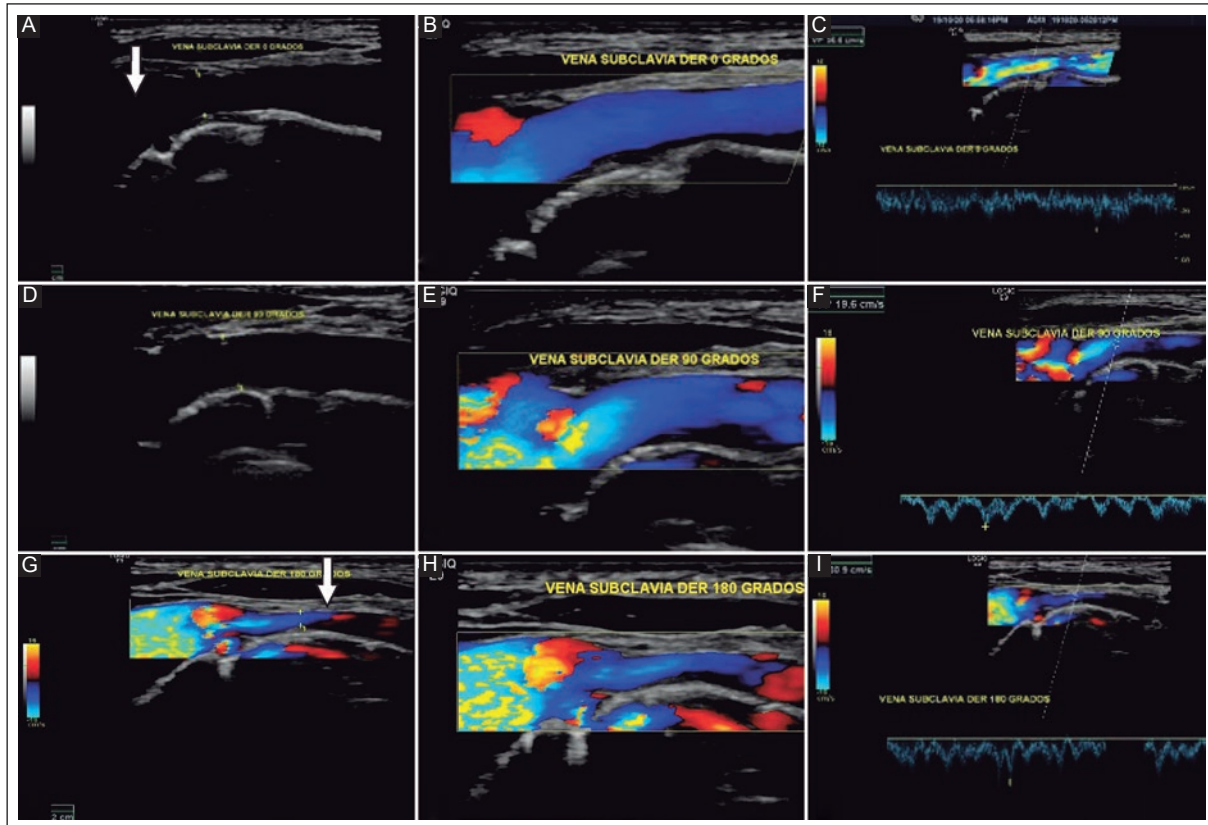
Normal US duplex Doppler of a 31-year-old male patient with dynamic maneuvers showing a normal diameter (A), patency (B), and flow velocity (C), in the subclavian vein at 0° 90° (D, E, F), and 180° (G, H, I), respectively. Physiological decrease in diameter was observed from 6.6 mm at 0° (A) (arrow) to 2.2 mm at 180° (G) (arrow).
